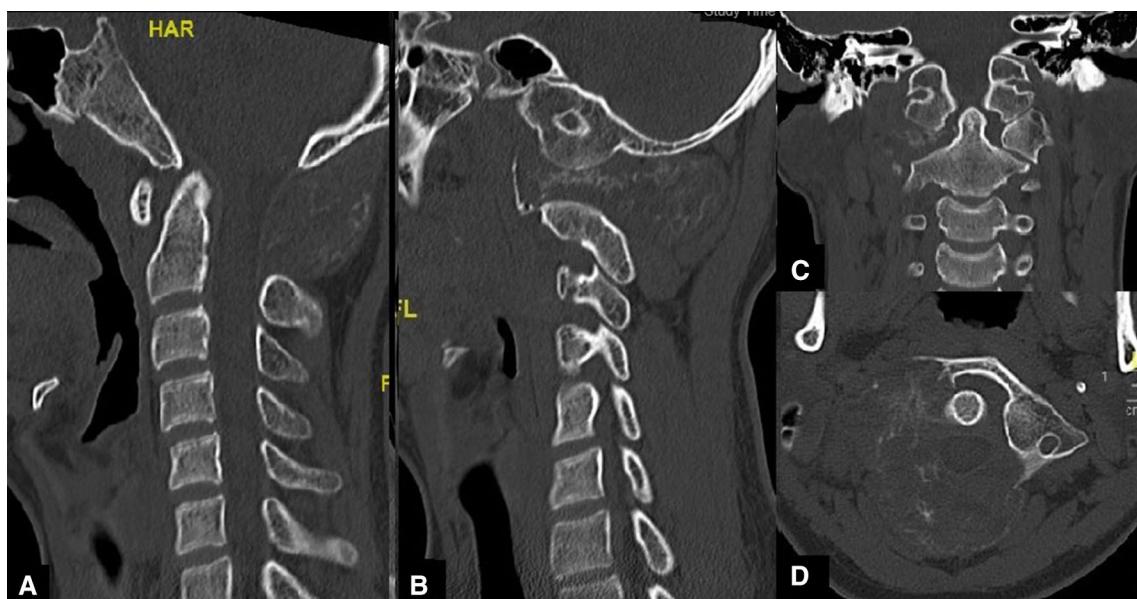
CT-Scan of 16-year-old male showing lytic lesion involving right lateral mass (b and c) and posterior arch (c). There is Fielding type I rotatory subluxation of C1–C2 (a). The cortices have been eroded by the expanding lesion
